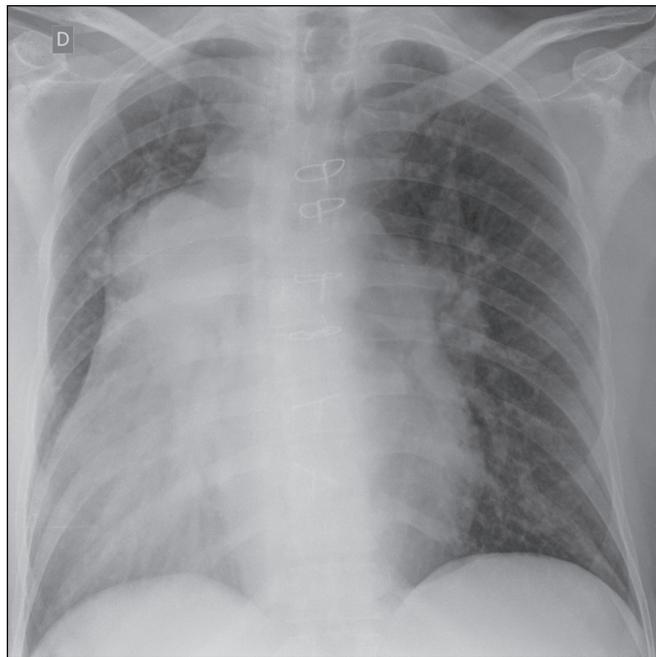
Chest X-ray showing dextrocardia, a widened mediastinum, and enlarged pulmonary arteries suggestive of pulmonary hypertension.
